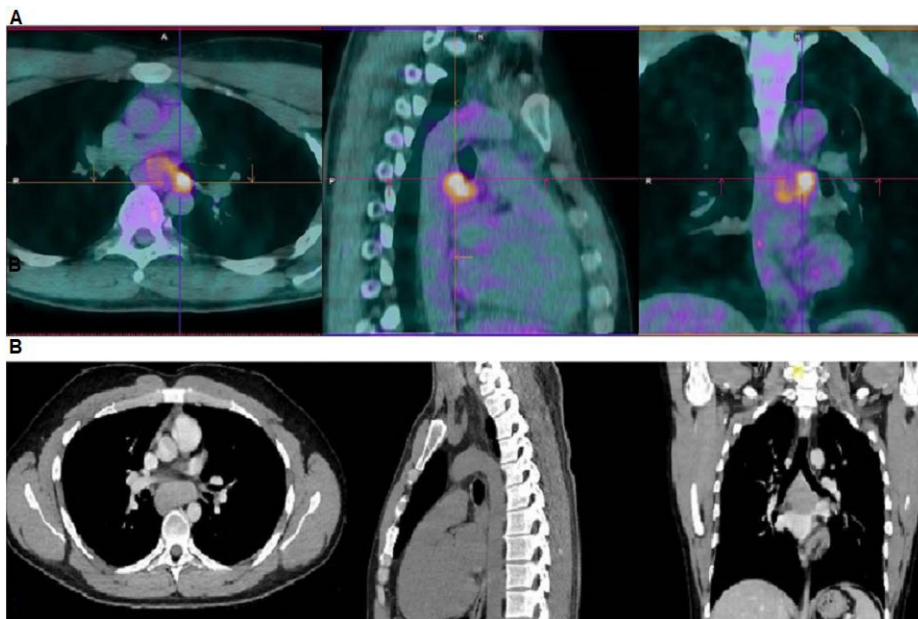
(A) Axial (left), sagittal (middle) and coronal (right) ^{18}F -FDG PET/CT fused views in a patient with Ewing sarcoma. A PET/CT performed during follow up showed a focal area of moderate FDG uptake ($\text{SUV}_{\text{max}} = 3.7$) in a small left para-esophageal lymph node, suspected for metastasis. (B) A contrast enhanced CT scan (Figure 1b) performed one month later showed a significant increase in the size of the lymph node (28 vs. 15 mm). The metastatic origin of the lymph node was then confirmed by transbronchial needle aspiration.
